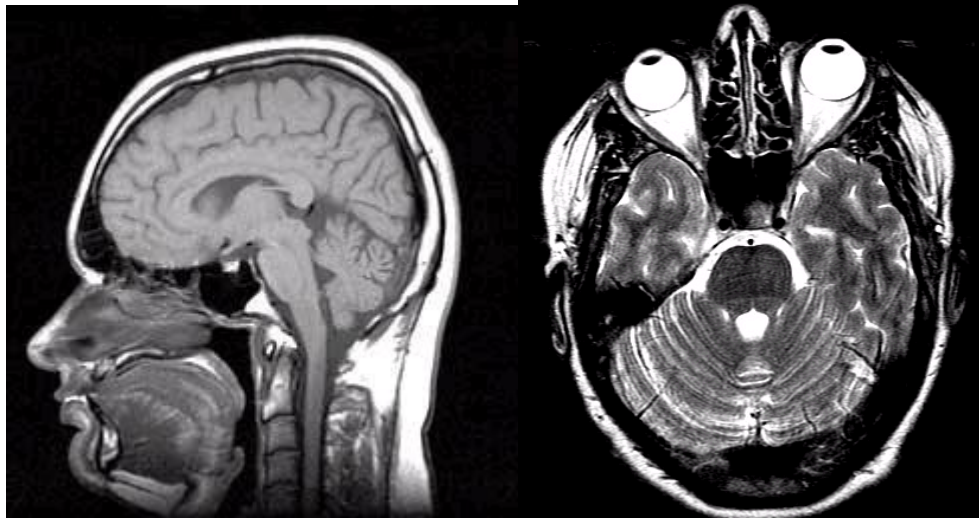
Normal MRI of the head in sagittal and axial projections.
